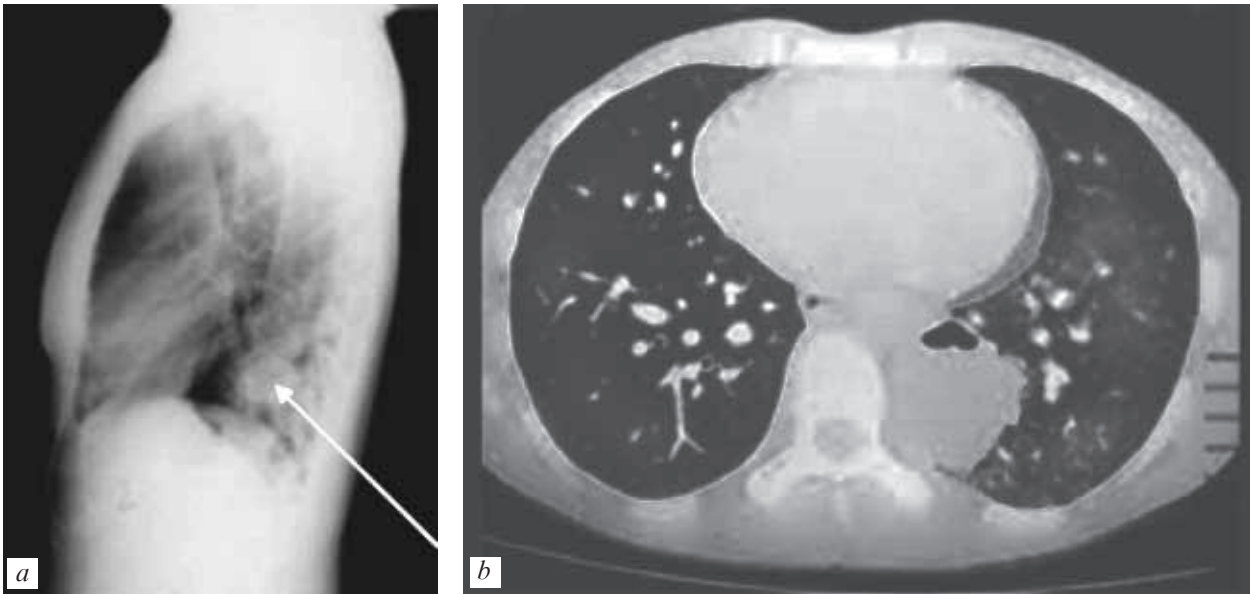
X-ray (a) and CT (b) of left-sided pulmonary sequestration
